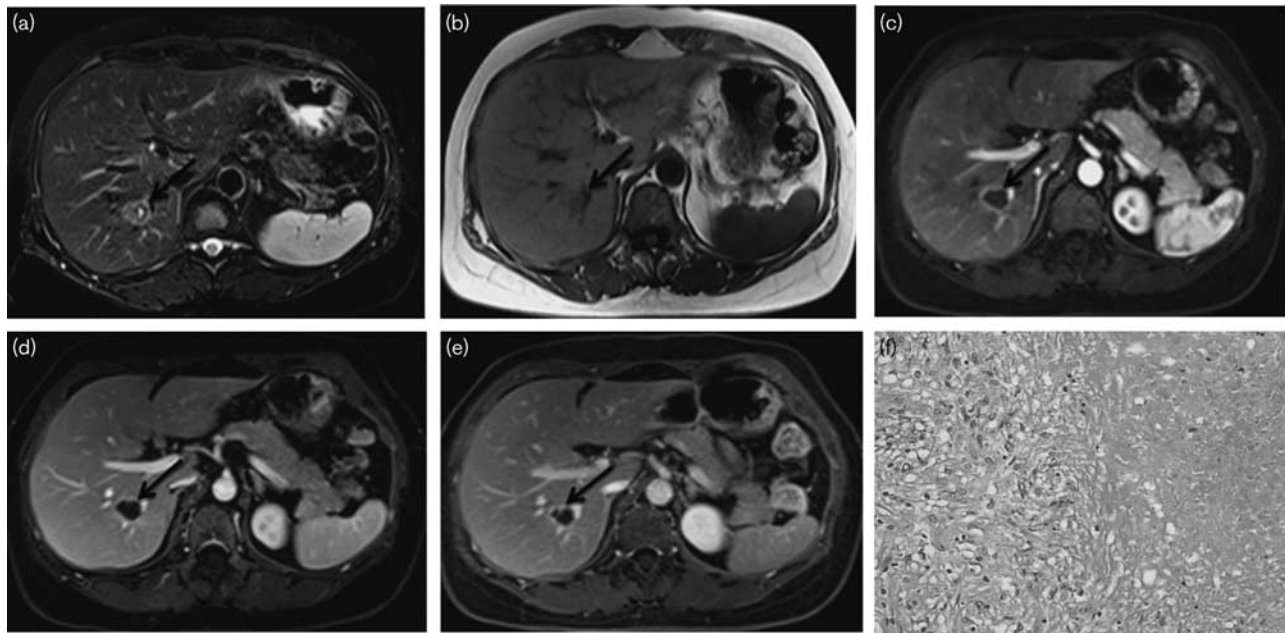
Small hepatic hemangioma in a 40-year-old woman (a–f). (a, b) MRI images of the nodule in segment VIII. The nodule is about 9 mm in diameter; by transverse T1WI, the nodule is hypointense and markedly hyperintense by transverse T2WI with distinct margin. (c–f) The arterial phase shows that the nodule has no significantly enhanced portion. The portal phase shows an enhancing dot in the nodule. The enhancement area is slightly enlarged 10 min after the injection of contrast material; however, a large area of persistent hypointensity remains. After 18 months, with the same acquisition time, the nodule has the same appearance as shown in (e).
